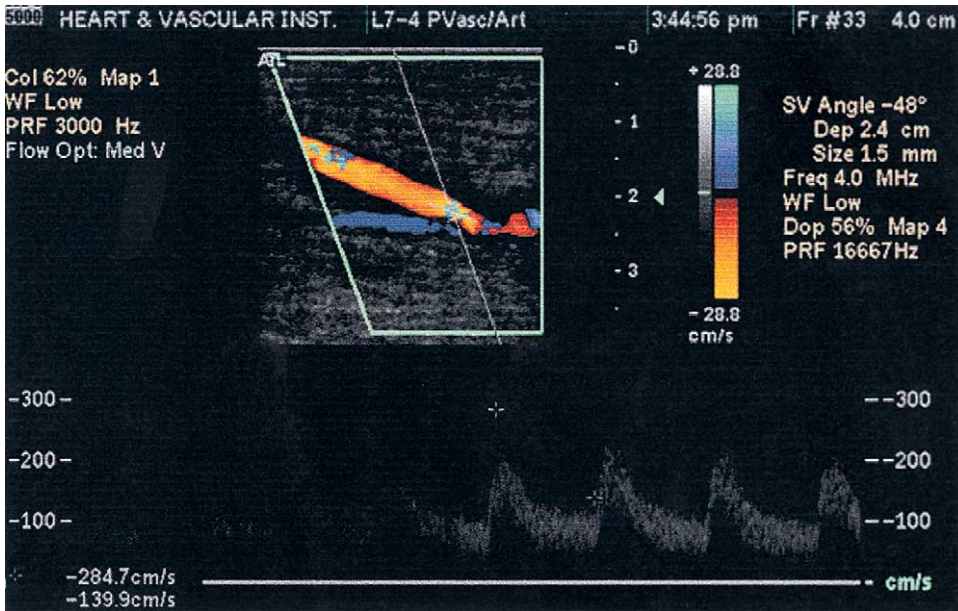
Arterial duplex ultrasound image of the distal anastomosis of a bypass graft. The peak systolic and end-diastolic velocities are 284.7 and 139.9 cm/s, respectively, correlating with a >75% stenosis.
